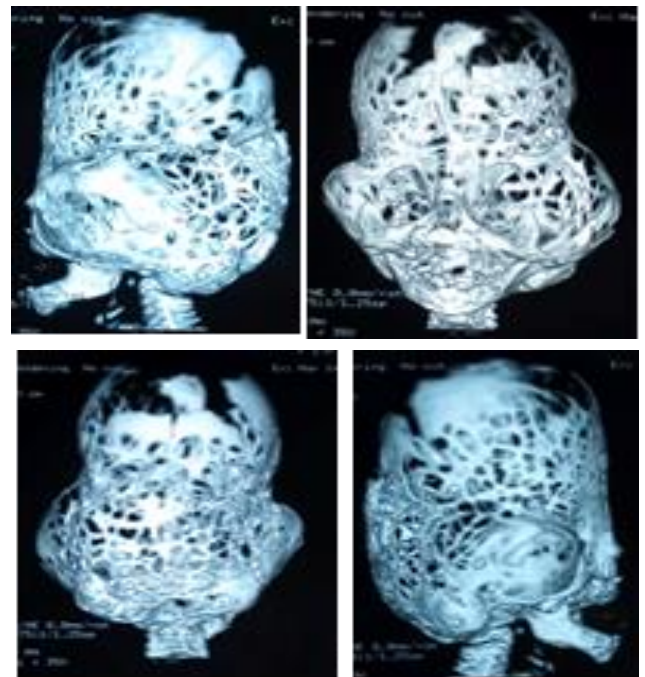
Cranial 3D reconstruction CT-Scan showed copper beaten appearance
